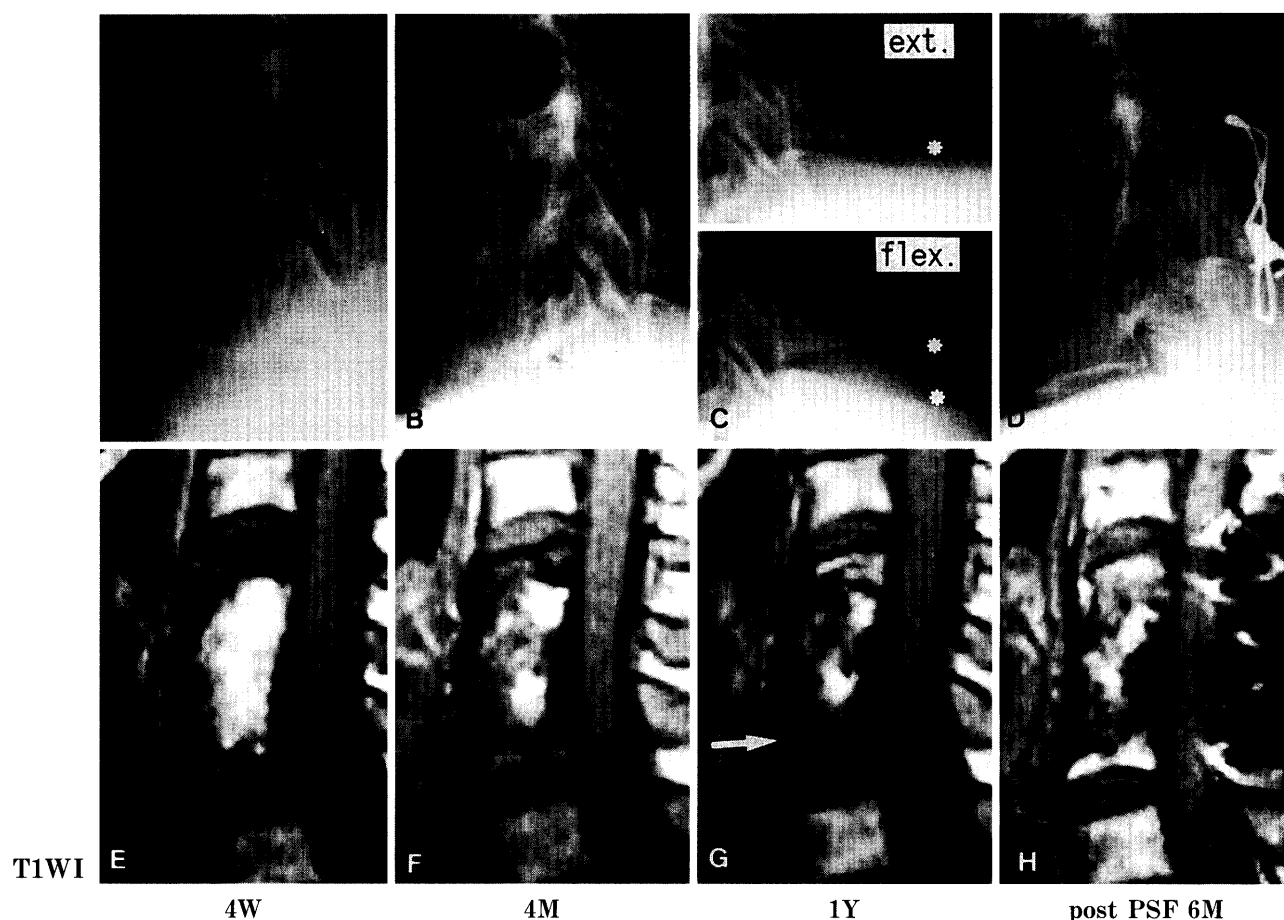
Representative Case 2. Backward titling and compression of the graft into the lower matrix has occurred (B). On the T1-weighted images, the graft shows a mosaic T1-PU3 pattern at four months after surgery (F). At one year, both the T1-PU3 and the change to low intensity of lower adjacent vertebra persist. It was decided that union was delayed (C and G). After additional posterior fusion surgery, the entire graft shows a nearly uniform isointensity on all images, and the change in intensity in C7 is no longer apparent (H).
